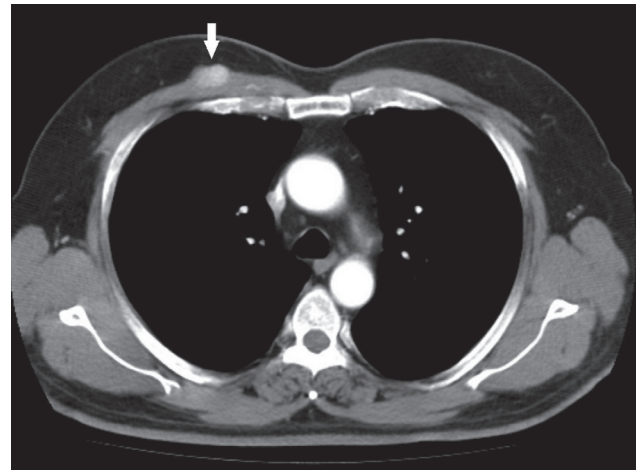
Thorax computed tomography showing intramuscular enhanced mass (arrow).
